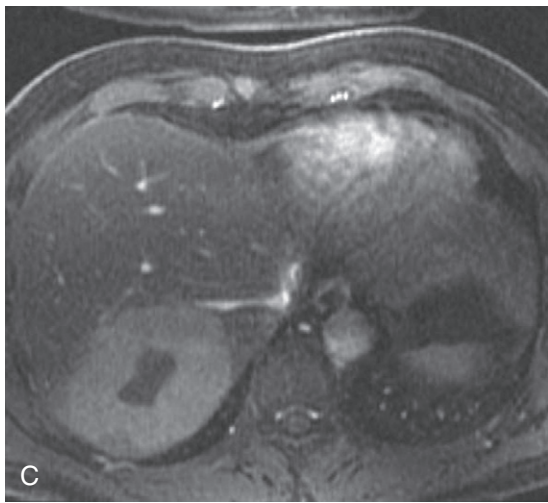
Complex hemangioma. The stellate central hypointensity (*arrow* in A) within the hyperintense hemangioma on the moderately T2-weighted image (A) fails to enhance on the delayed image (B).
